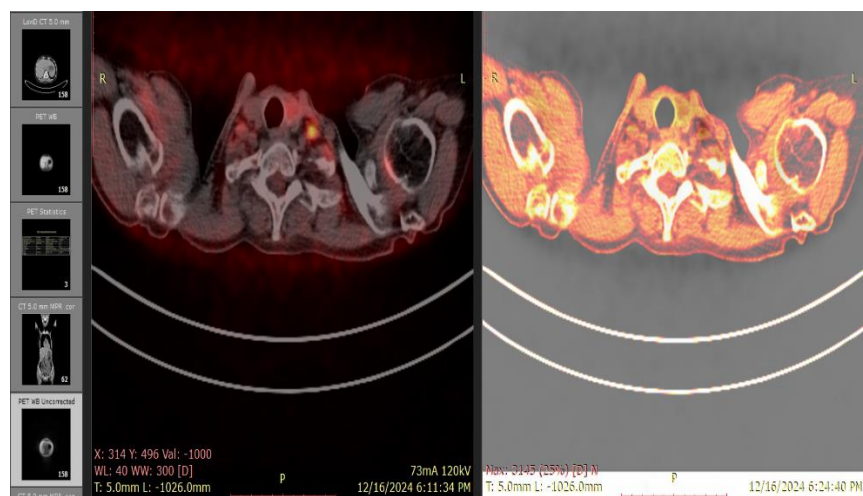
PET CT on 16 December 2024.
